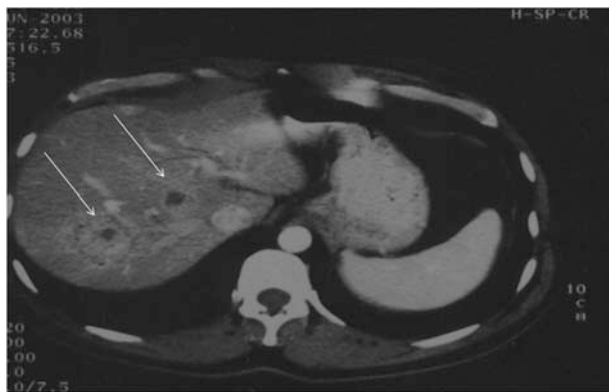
Computed tomography scan from June 20, 2003, shows stable hepatic parenchymal lesions as compared to February 24, 2003 (arrows).
